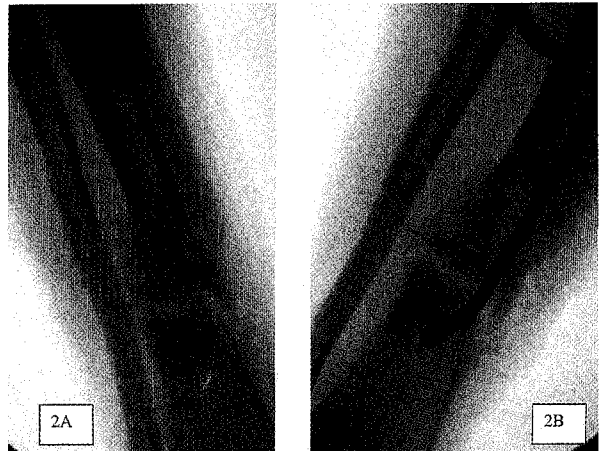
Surgical technique Image intensifier radiograph shows non-ball-tip guide wire introduced to the non-union site. The fibrous tissue was perforated with the reamer until distal the medullary canal.
